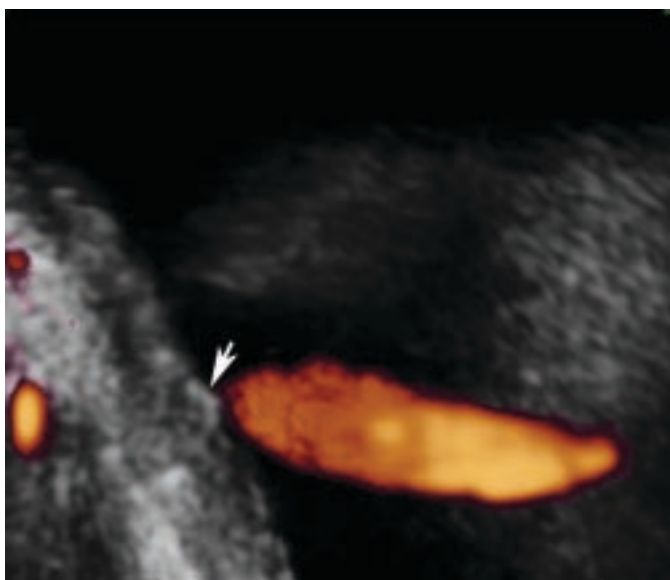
Ureter jet phenomenon. Power Doppler demonstrating urinary flow emitting from the ureter papilla (arrow).
